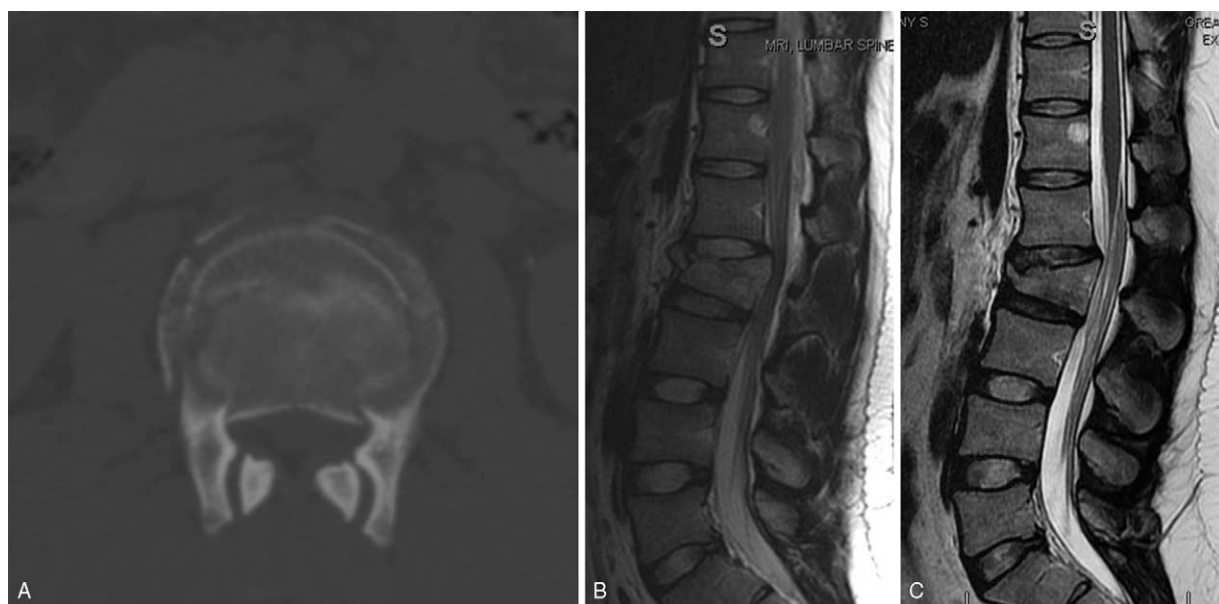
A 19-year-old man fell from a height of 20 feet sustaining an L1 burst fracture without neurological deficit. CT scan (A) reveals the retropulsion of bone and a residual canal of 75%. Sagittal T-2 weighted MRI (B) shows the canal compromise and minimal kyphosis at 3° . Though the posterior longitudinal ligament is stretched, the inter- and supraspinous ligaments and ligamentum flavum are preserved. The patient was treated nonoperatively and returned 8 years later with complaints of back and leg pain for 6 months. Sagittal T-2 MRI (C) shows remodeling of the spine without significant canal compromise, but persistence of kyphosis now measuring 11° . Patient is being treated conservatively with anti-inflammatories.
